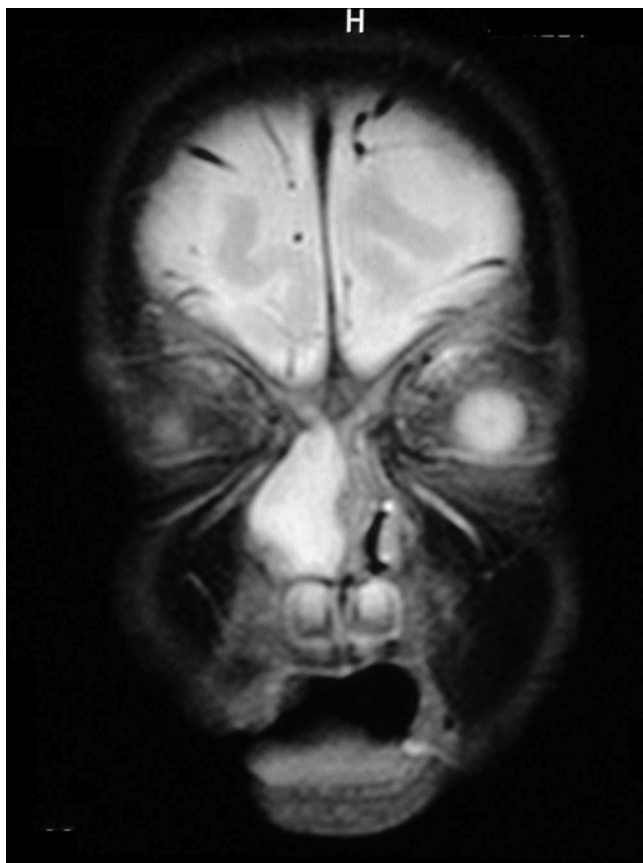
Coronal MRI of Transethmoidal encephalocele
